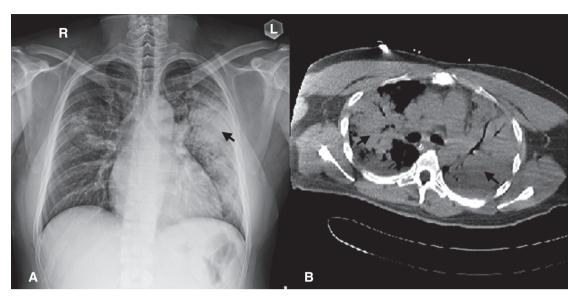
Initial chest radiograph demonstrated (A) bilateral, peripherally predominant lung opacities (black arrow) and rapid progression of lung infiltrations after transferring to the ward. (B) Chest CT demonstrated bilateral consolidation with air-bronchogram (black arrows).
